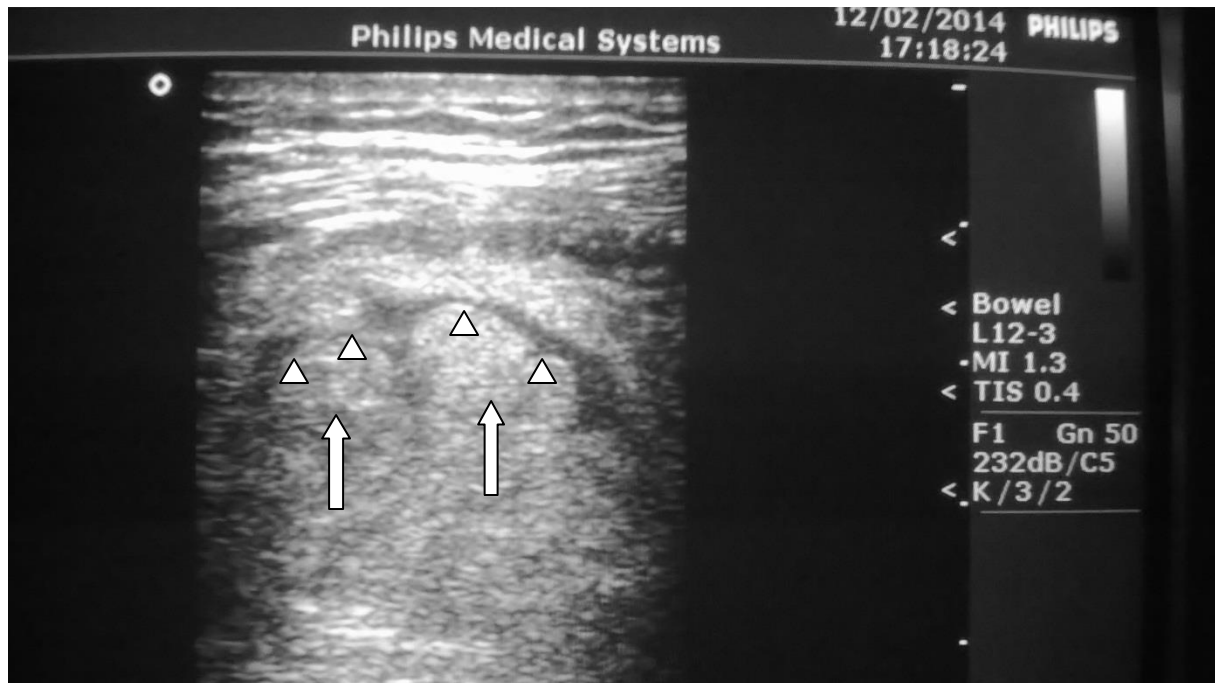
Ultrasonography demonstrated a hyperchoic structure (arrows) with surrounding hypoechoic line corresponding to thickened visceral peritoneum (arrow heads).
